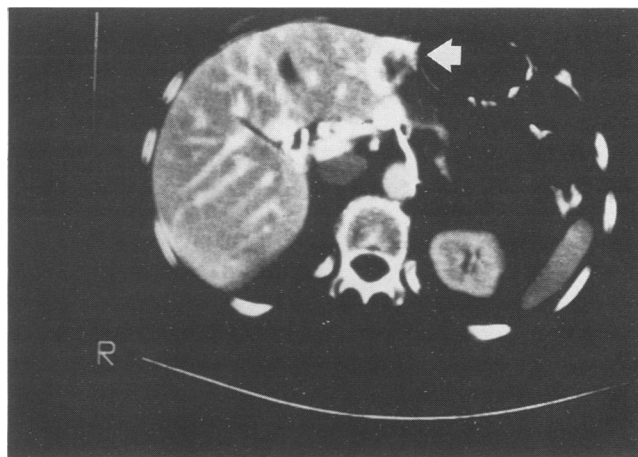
Computed tomographic arterial portography in a patient with a previously demonstrated large right lobe lesion. This cut suggests numerous lesions in the right lobe lesion with a possible cyst in the left lateral segment (arrow).
